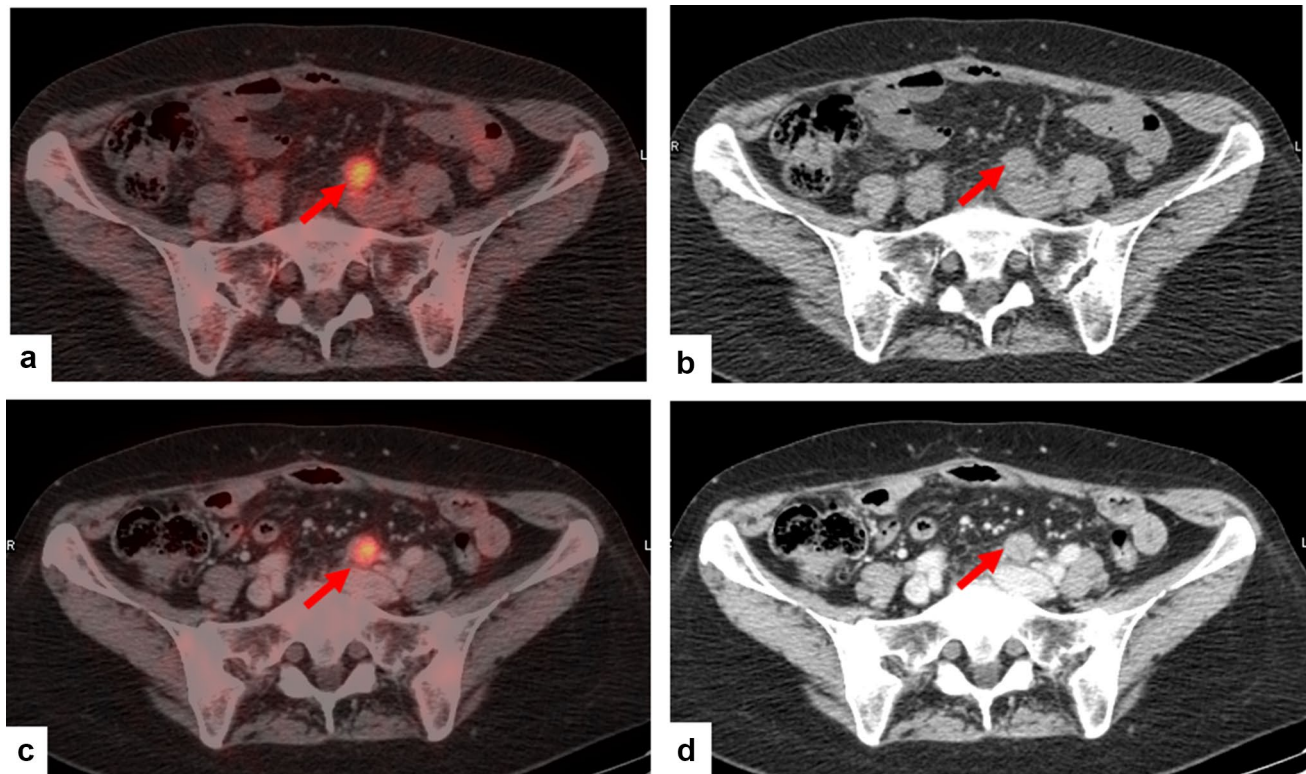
Sixty-two-year-old female with suspected OC relapse. Both ^{18}F -FDG PET/IdCT (a, b) and ^{18}F -FDG PET/CeCT (c, d) clearly detected a focal tracer uptake corresponding to a pathological left iliac lymph node (red arrows)
